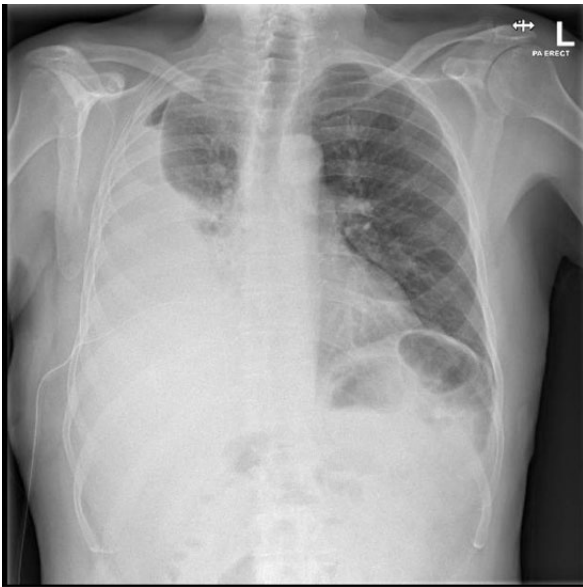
A post-drain insertion chest radiograph with a resultant hydropneumothorax. This is shown by the appearance of the pocket of air at the right apex on top of the white opacification, which is the fluid.
